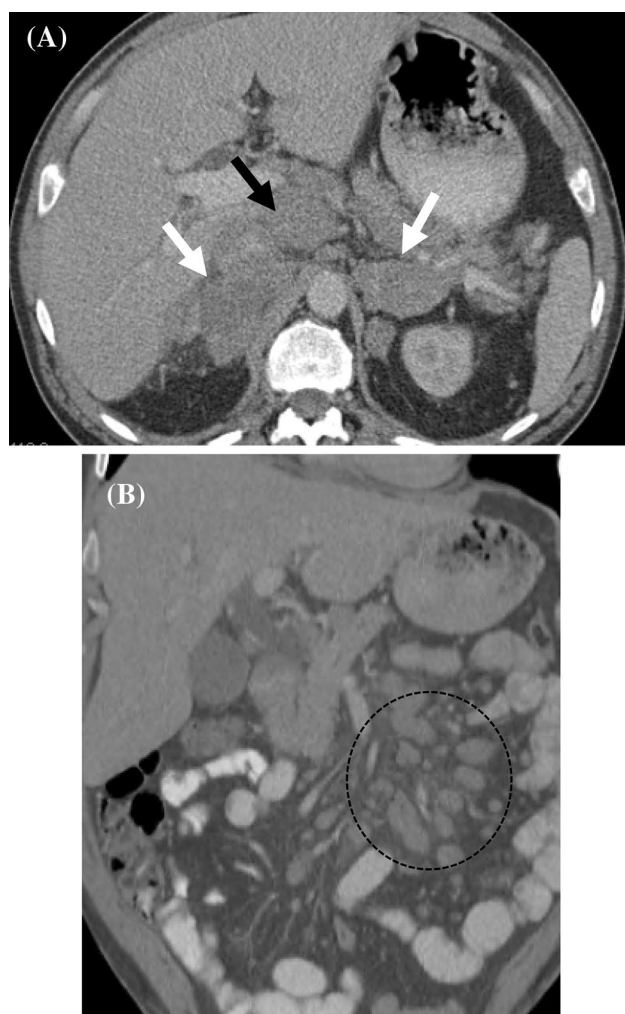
A 50-year-old male patient with abdominal lymphoma and secondary bilateral adrenal involvement. a Axial contrast-enhanced abdominal CT shows bilateral hypoattenuating adrenal masses (white arrows) and enlarged porta hepatis lymph nodes (black arrow). b Coronal contrast-enhanced abdominal CT of the same patient shows mesenteric adenopathy (circle)
